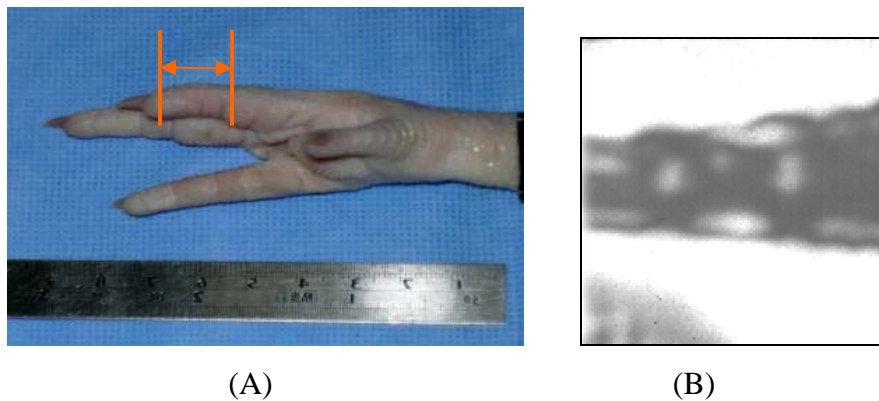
(A) The test sample with marked portion was used in the experiment. The dimensions of the sample are ~2.5cm in length, ~0.6cm in diameter (tip of the chicken finger) and ~0.9cm in diameter (bottom of the sample). (B) The C-scan ultrasound image of the testing sample.
